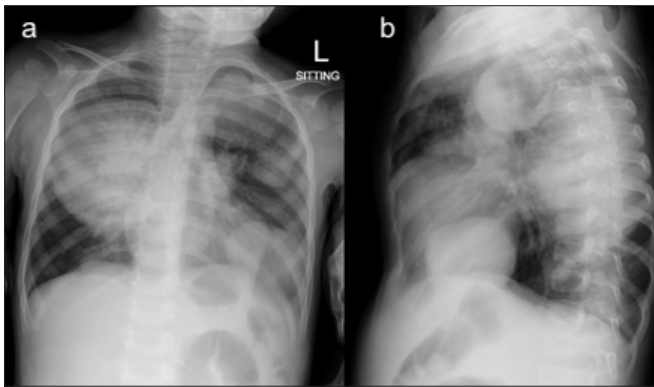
A and B. Frontal (a) and lateral (b) chest radiographs in a 3-year-old boy demonstrating multiple, bilateral, large, varying-sized oval masses involving the lung parenchyma of the right lower lobe (apical and basal segments) and the left lower and upper lobes. In addition, there is mild cardiomegaly with a displaced cardiac apex.
